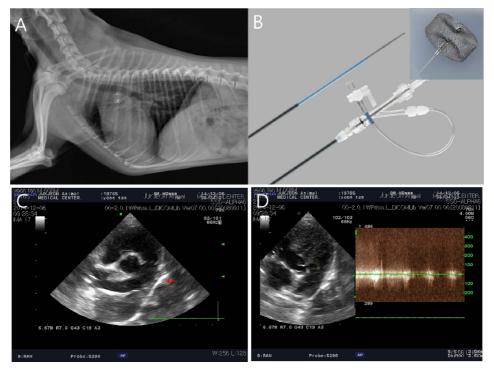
Diagnostic imaging studies after successful occlusion in this case. A: The thoracic radiography taken after the ductal occlusion revealed successful occlusion of PDA. B: Amplazer® vascular plug (inset) and the delivery system (Flexor® Shuttle® Guiding Sheath, Cook medical, USA). C: 2D echocardiography revealed successful occlusion of ductus arteriosus. Arrow indicate vascular plug at the ductus arteriosus. D: Continuous wave Doppler echocardiography revealed minimal residual shunt at the ductus arteriosus.
